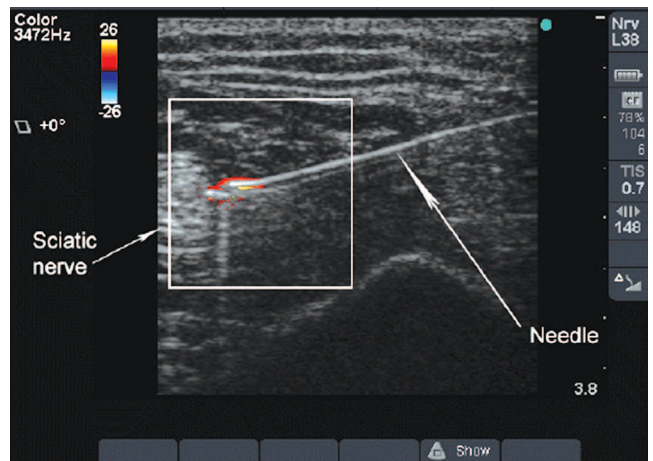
Posterior to anterior, short axis, color Doppler mode ultrasound image of the sciatic nerve using a 12 MHz L38 probe (MicroMaxx, Sonosite). The piezoelectric modified Tuohy needle (Contiplex, B. Braun) is approaching the sciatic nerve from lateral to medial. The function generator (FG502, Tektronix) coupled to a 100 W audio amplifier (R3000, KLH) is turned on. The red colored area surrounds the needle tip.
